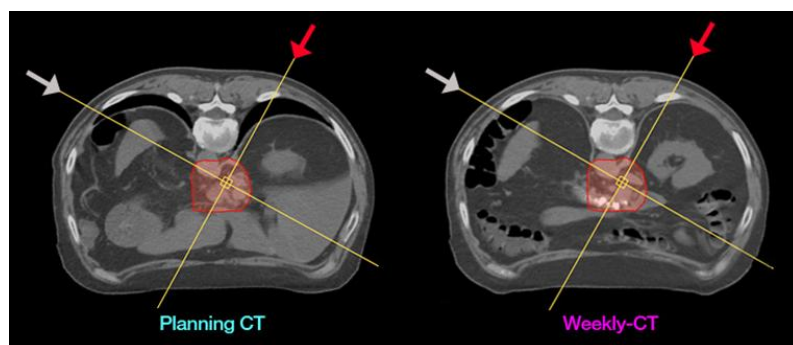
Example of patient B showing tissue variation along the beam path for same slice in planning-CT and weekly-CT. (Red arrow= active field direction, grey arrow= inactive field direction during the WEPL calculation)
